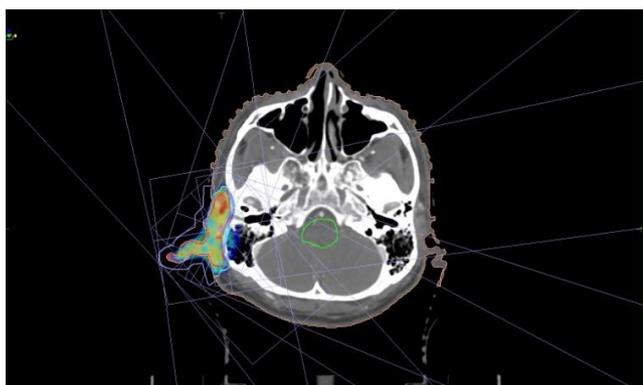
IMRT plan on planning CT scan. It shows 9 field IMRT plan, virtual bolus and 100 % dose wash.
